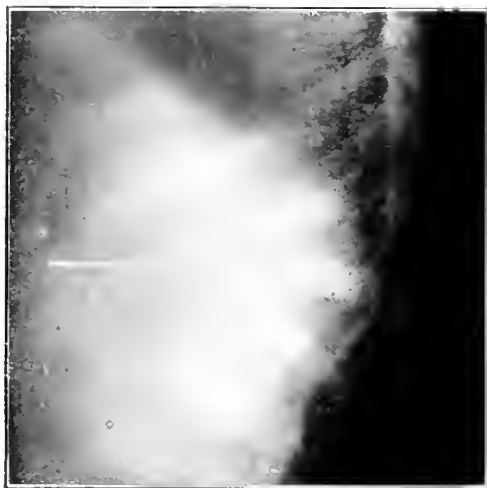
Ita P. Roentgenogram showing lateral view of the wedge shaped vertebra.
